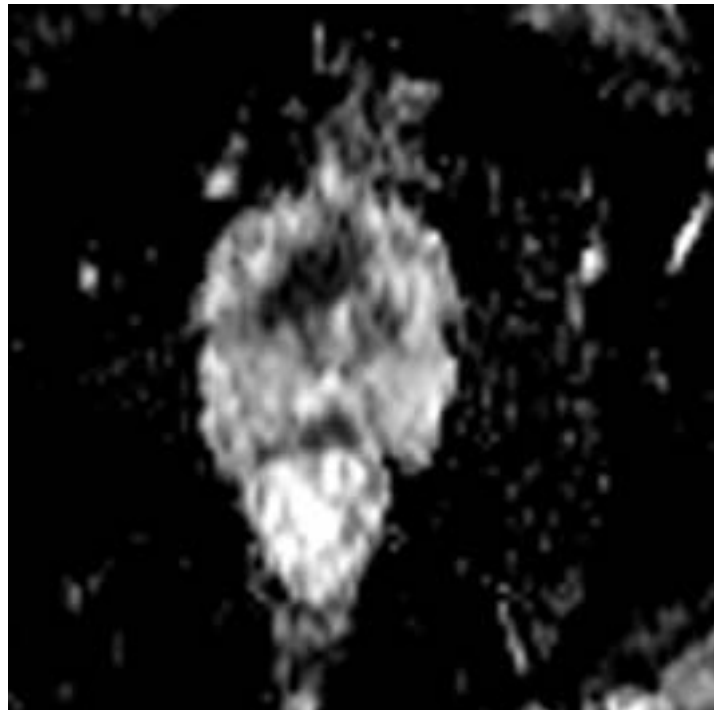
a T2WI, 8.b DWI & 8.c ADC : Large smooth homogeneous hypointense area on T2WI noted in the TZ/AFS. There is high signal on DWI and a decrease in ADC categorized PIRADS V in the transitional zone
